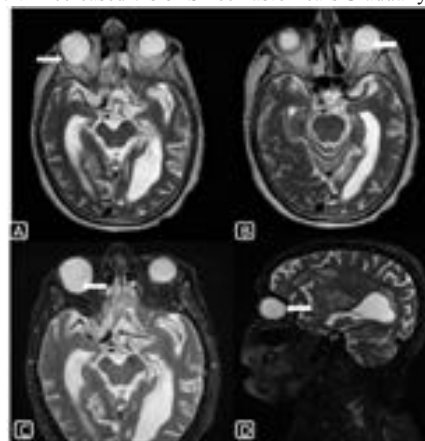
Axial (A, B AND C) and sagittal (D) T2WI of MRI brain and orbit showing enlargement of both eye balls secondary to glaucoma(white arrows).
